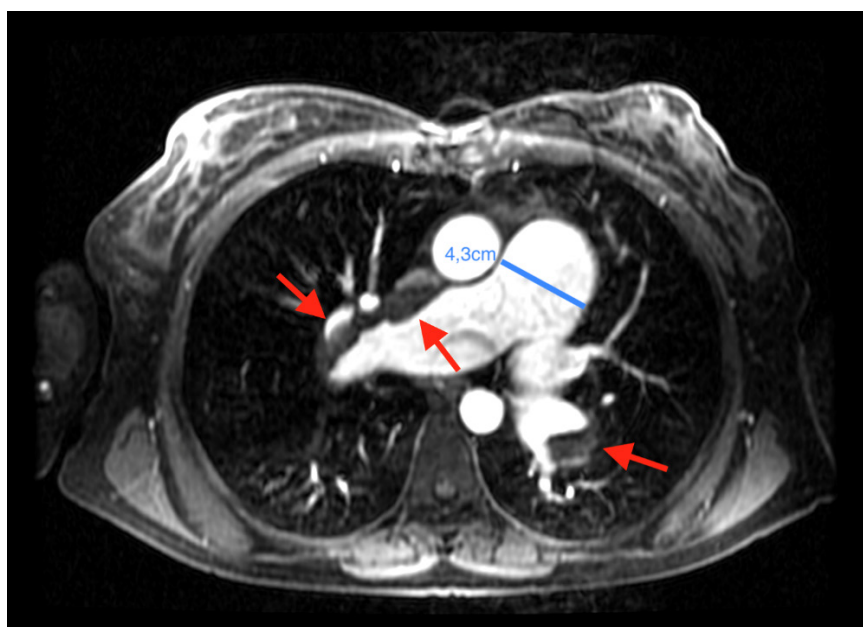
Cardiac magnetic resonance imaging showing thromboembolism in the right pulmonary artery (red arrow) and an enlarged pulmonary artery trunk.
